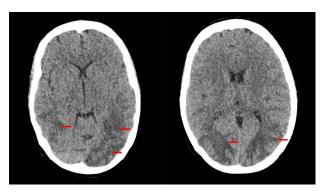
Brain CT-scan showing areas of hypo attenuation involving predominantly the sub-cortical white matter in both occipital lobes right greater than left (Red arrows).
